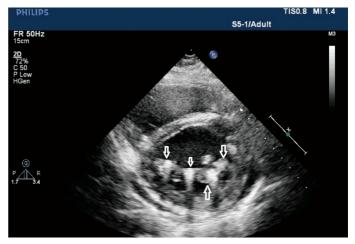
Parasternal short-axis view in transthoracic echocardiography demonstrates four MitraClips on the mitral valve position after 6 months (white arrows)
